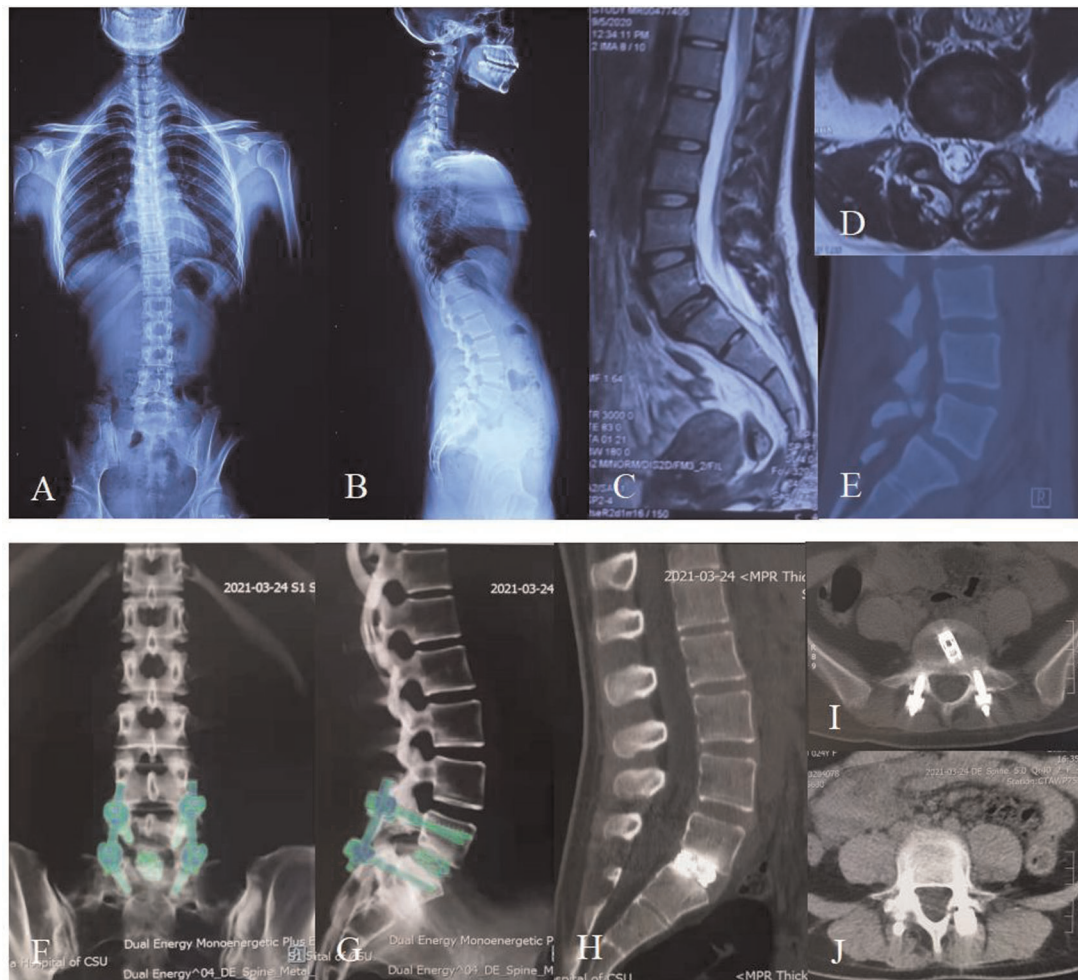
Twenty-four-year-old female with 10-month lumbar pain and half-month left leg pain. (A,B) Preoperative X-ray showing the patient had a degenerative L5/S1 spondylolisthesis up to Grade I according to the Meyerding standard and had a slightly degenerative lumbar scoliosis. (C) Preoperative sagittal MRI showing the patient had an L5/S1 spondylolisthesis and multi-level disc degeneration. (D) Preoperative cross-sectional MRI showing that the spondylolisthesis in L5/S1 led to a stenosis of left lateral recess. (E) Preoperative sagittal CT showing an isthmus fissure in L5 and spondylolisthesis in L5/S1. (F,G) The postoperative dual energy CT showing that the cage and pedicle screws were complete and in position at the follow-up of 6 months after surgery. (H-J) The postoperative CT showing a sign of fusion within the interbody of L5/S1 at the follow-up of 9 months after surgery, and the fixation instruments were complete and in position.
